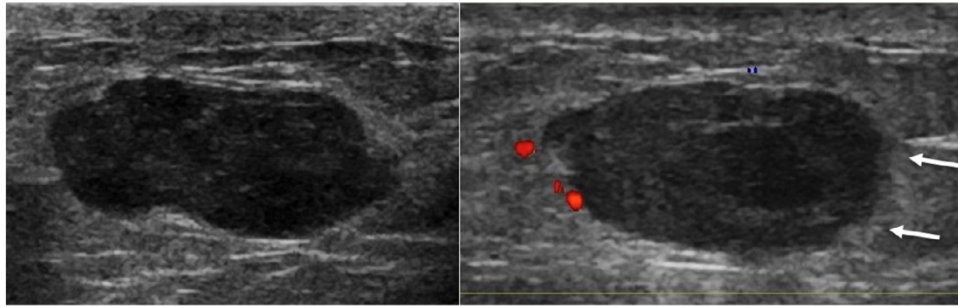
Transverse and longitudinal views with targeted ultrasound of the right breast mass demonstrate an oval, parallel, hypoechoic mass with not circumscribed (microlobulated) margins (arrows) measuring 2.5 × 2.9 × 1.1 cm in the 6 o'clock retroareolar region.
